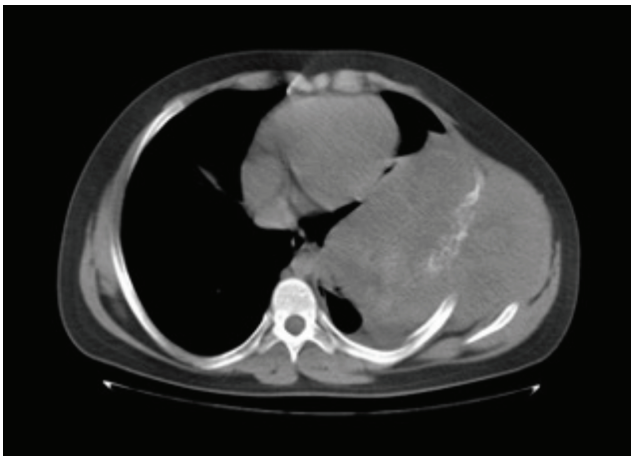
14-year-old boy with PNET. Axial non-contrast computed tomography scan demonstrates an extra-pleural giant heterogeneous solid mass causing osseous destruction of the left lateral 6th rib. The mass extends into the left chest wall and hemithorax
